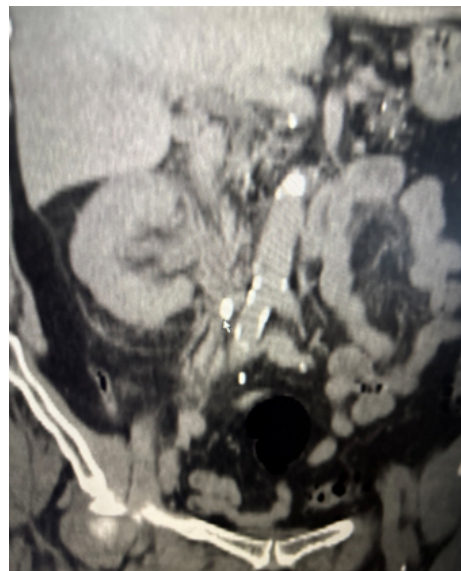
CT scan- right ureter calculus.
